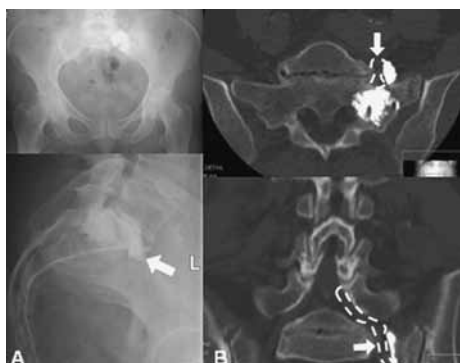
Sacral insufficiency fracture due to osteoporosis was treated with sacroplasty in a 64 year-old woman. Anterior cement leakage and cement leakage in the disc space L5-S1 were observed in (A) postoperative plain radiographs. Three weeks postoperatively the patient made an unscheduled visit to the outpatient service complaining of the sudden appearance of a radiculopathy of the 5th, left-sided lumbar nerve root without neurologic deficits. On (B) coronal and axial CT scans hour-glass-like compression of the left 5th lumbar nerve root was seen (white dashed line). The symptoms could be relieved by the use of oral intake and local, paraforaminal injections of corticosteroids.
